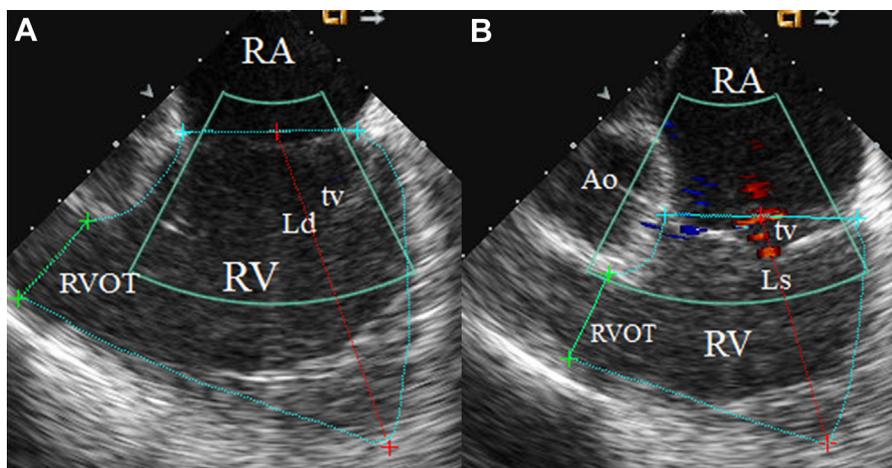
Intracardiac Echocardiographic Imaging With the Transducer Placed in the Right Atrium Showing a Right Ventricular Inflow View
